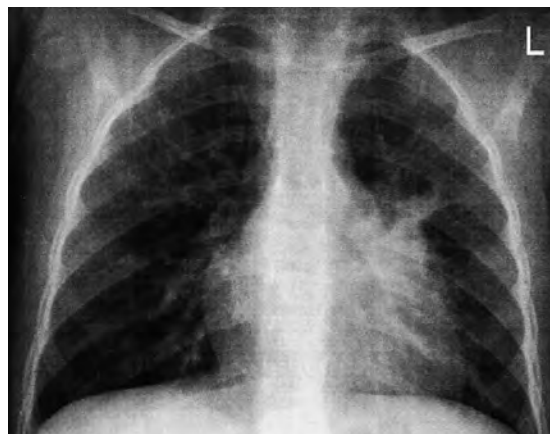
Chest X-ray at COVID-19 diagnosis
